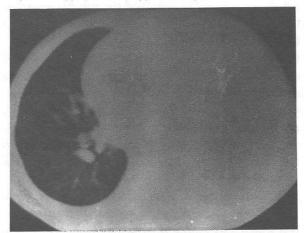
Initial chest roentgenogram shows complete opacification of the left hemithorax. B. CT scan of the chest shows large amount of fibrinous debris, which almost completely collapsed the left lung.
